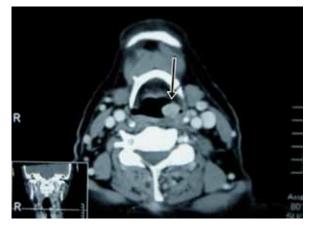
Neck computed tomogram image showing a laryngeal mass at the posterior pharyngeal wall (arrow).
